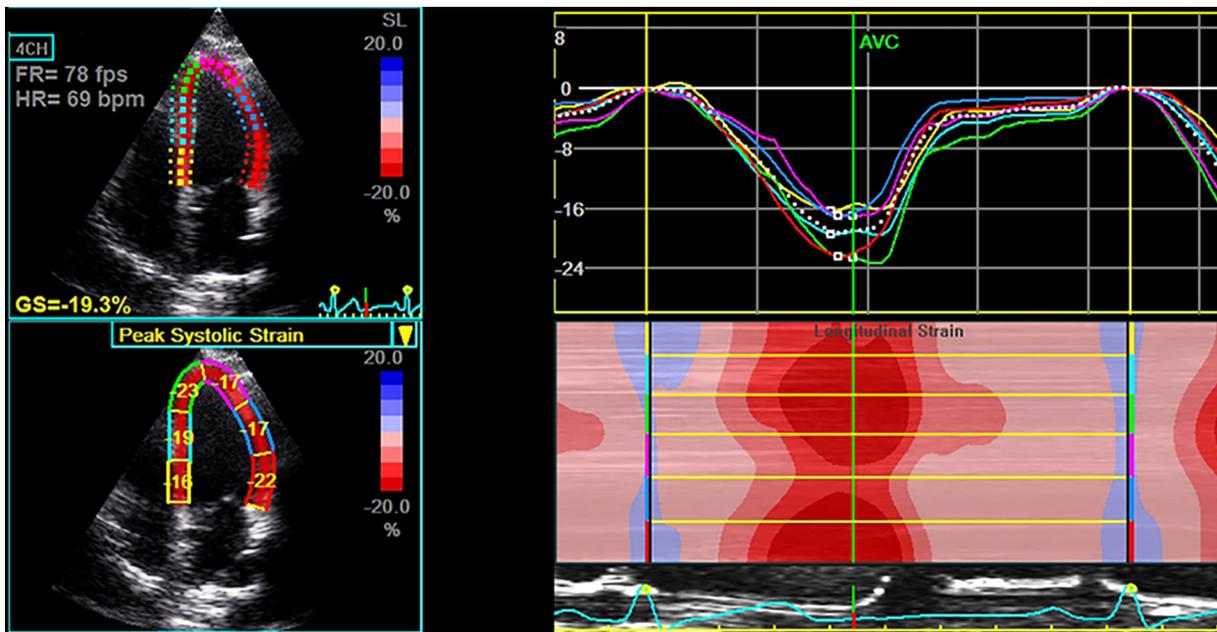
The longitudinal strain in three myocardial layers at the apical four-chamber plane. The myocardial wall is defined with multiple chains of nodes for allowing assessment of longitudinal endocardial, mid-myocardial and epicardial strains in the end-systolic frame of the image (left panel). The related strain curves for the six segments and color-coded strain image within the longitudinal-axis view are given in the right panel. Color lines indicate regional strain; white dotted line means global (average) strain.
